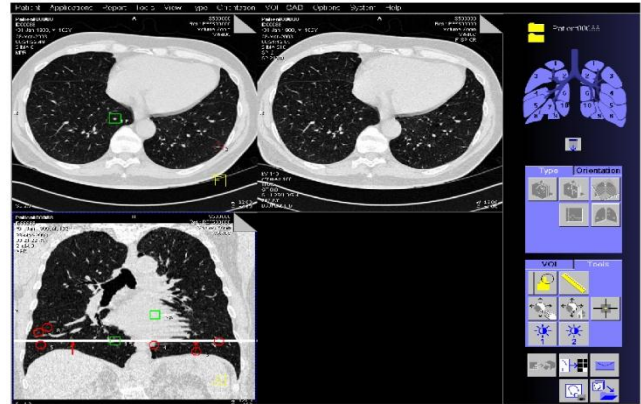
Suspicious regions highlighted on a Lung CT.
